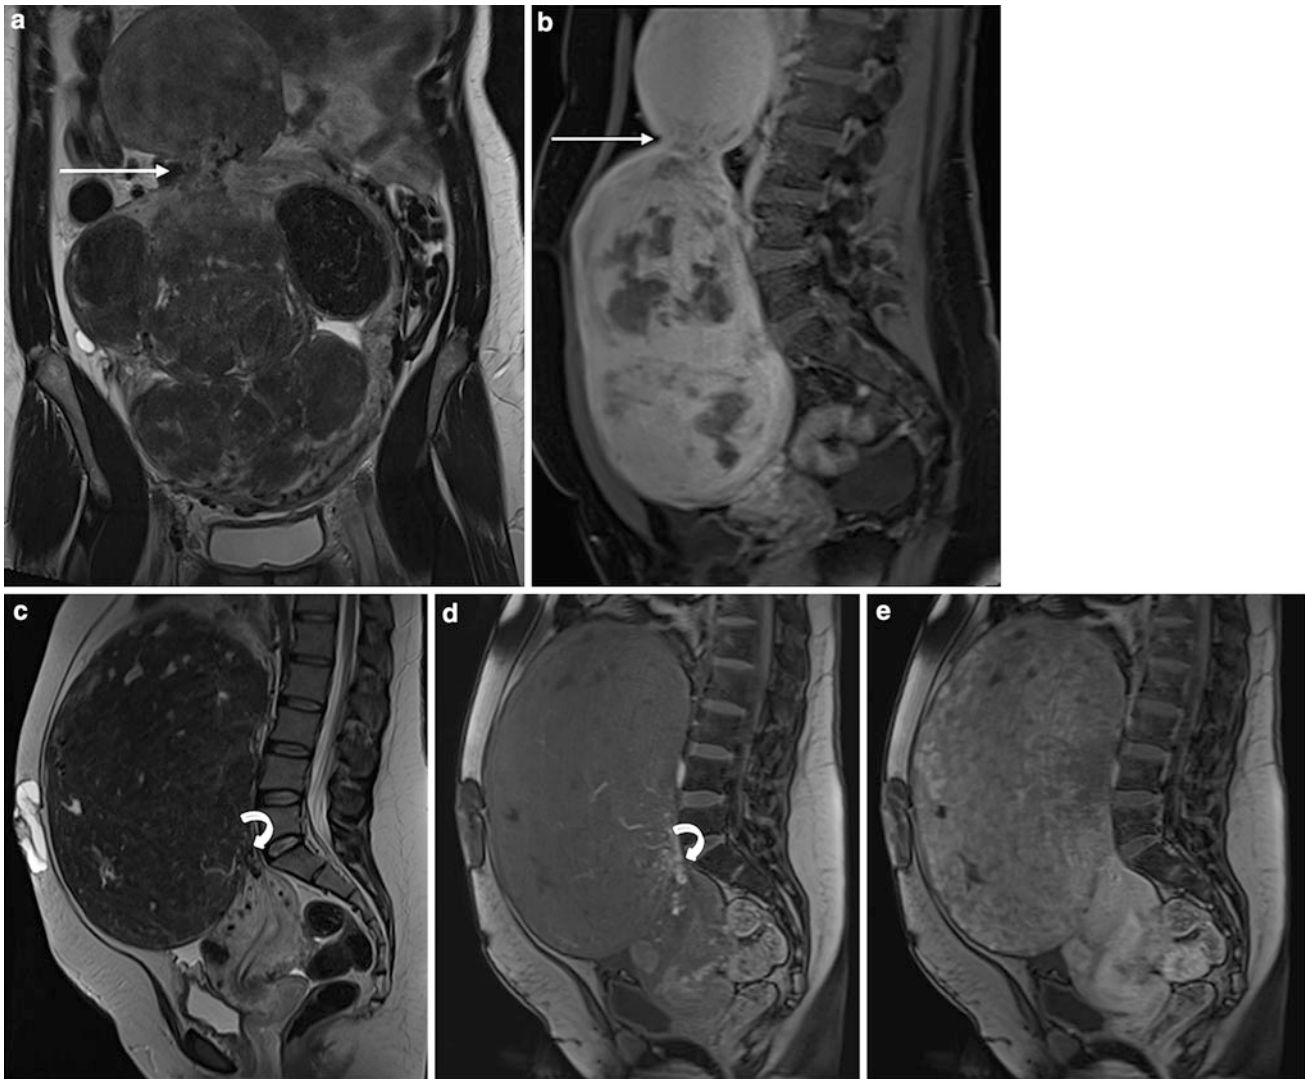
a Coronal T2 and b Sagittal T1FS contrast-enhanced MRI in a patient with multiple fibroids. There is a dominant pedunculated fibroid on a narrow stalk (*arrow*) arising from the uterine fundus which is markedly vascular. Despite this, the patient was referred for UAE given the presence of multiple other fibroids and a combination of bleeding and pressure symptoms. c T2 sagittal MRI in a different
